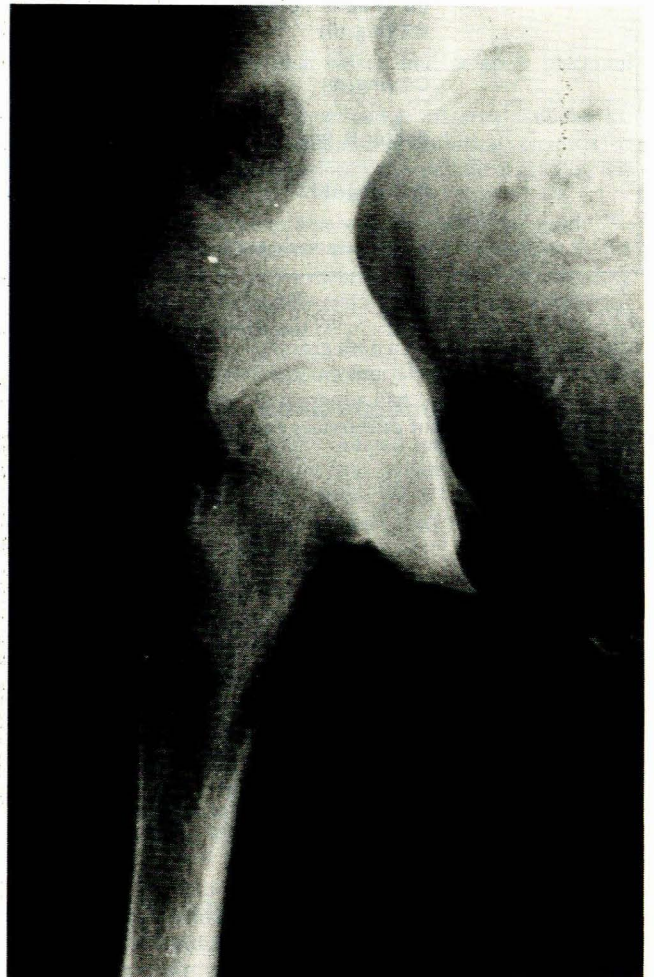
The initial radiograph of the right hip showing the features of idiopathic chondrolysis.
